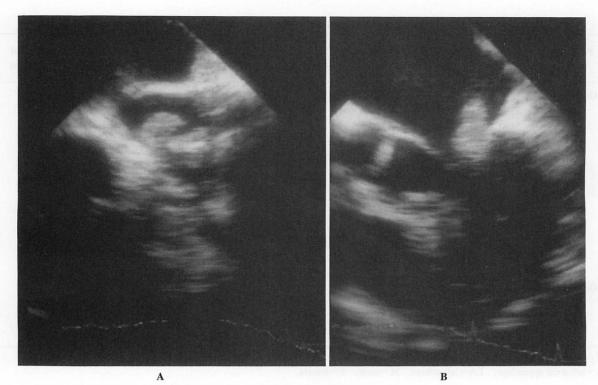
Transesophageal echocardiograms of a patient with re-embolization (case 3)
